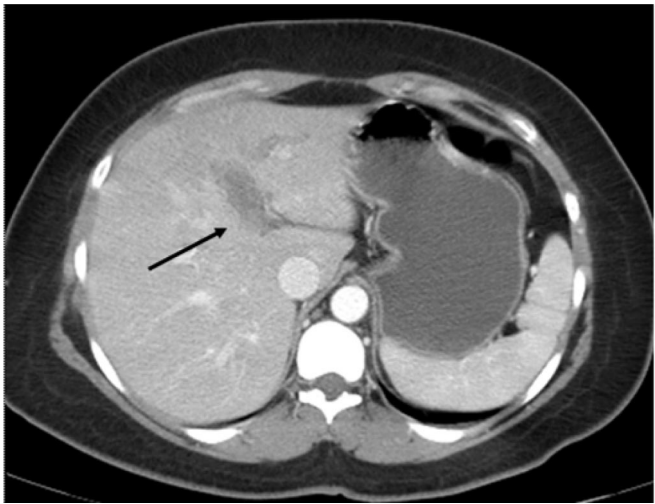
Computed tomography of the abdomen demonstrating left PVT (arrow).
